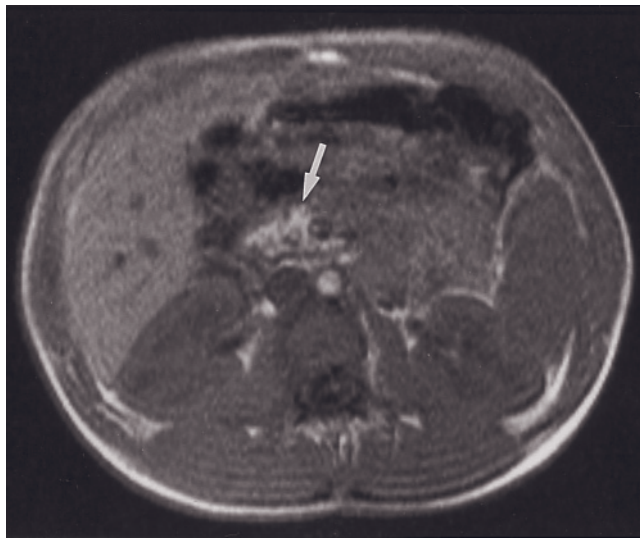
Cystic fibrosis. T1-weighted SGE (a), immediate postgadolinium T1-weighted SGE (b), and 90-s postgadolinium T1-weighted fat-suppressed SGE (c) images in a patient with cystic fibrosis. The pancreas is markedly enlarged and hyperintense on
